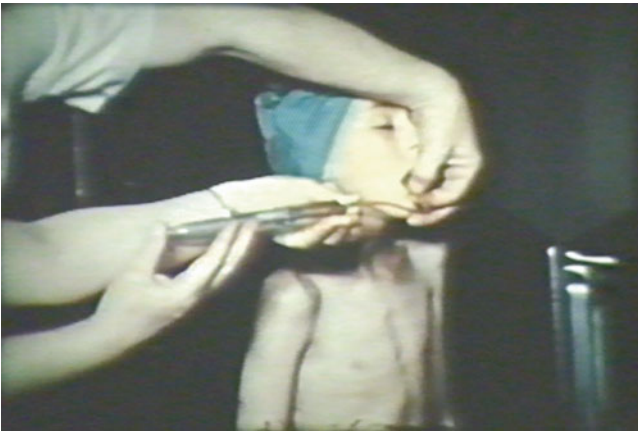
A cachectic child undergoing intrapulmonary contrast injection via an intratracheal catheter for radiographic evaluation of tuberculosis. The tracheobronchial tree was topically anesthetized with local anesthetic, and intermittent sedation was provided by the inhalation of nitrous oxide (From a pediatric anesthesia training film made by Dr. M. Digby-Leigh in 1947)
